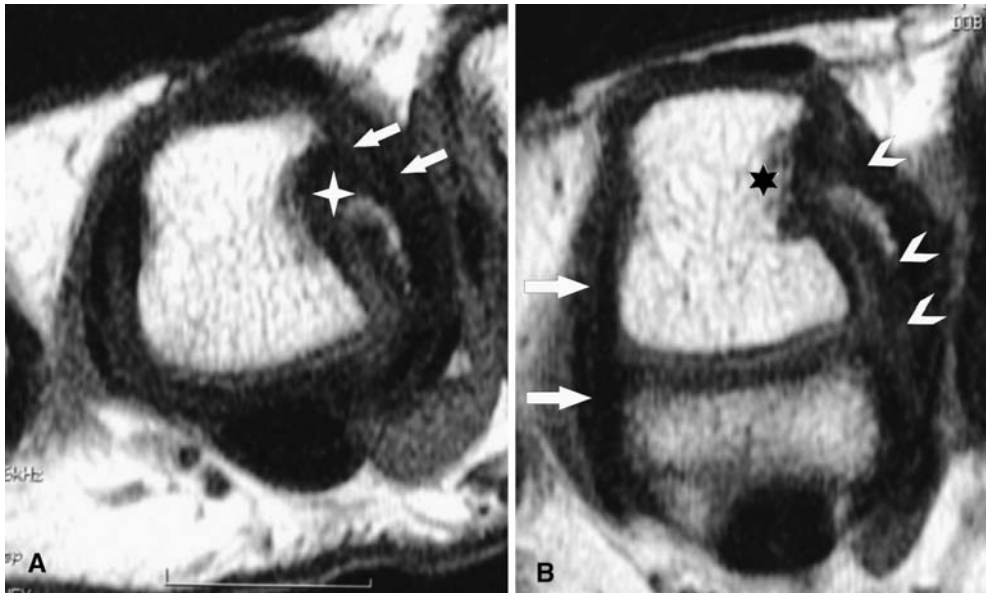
MR images of a partial tear of the radial collateral ligament of the fourth right MCP joint. Axial T1-weighted (560/15) images of A the extended MCP joint and B the flexed MCP joint, the latter performed following intravenous contrast administration. In extension, the radial collateral ligament appears continuous but its proximal insertion is thickened (*white star*) and surrounded by
